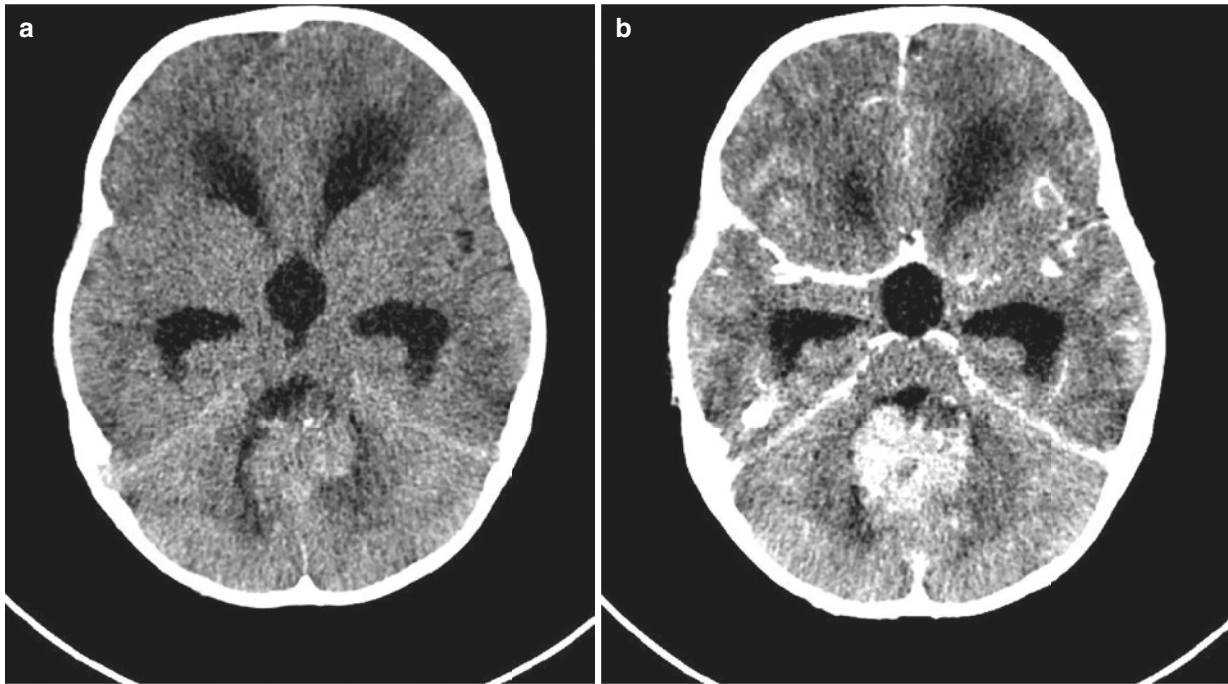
Ependymoma. (a) Axial CT image shows a dense mass arising from the fourth ventricle, containing a tiny fleck of calcification. There is hydrocephalus involving the lateral and third ventricles. (b) The tumour enhances following contrast administration
